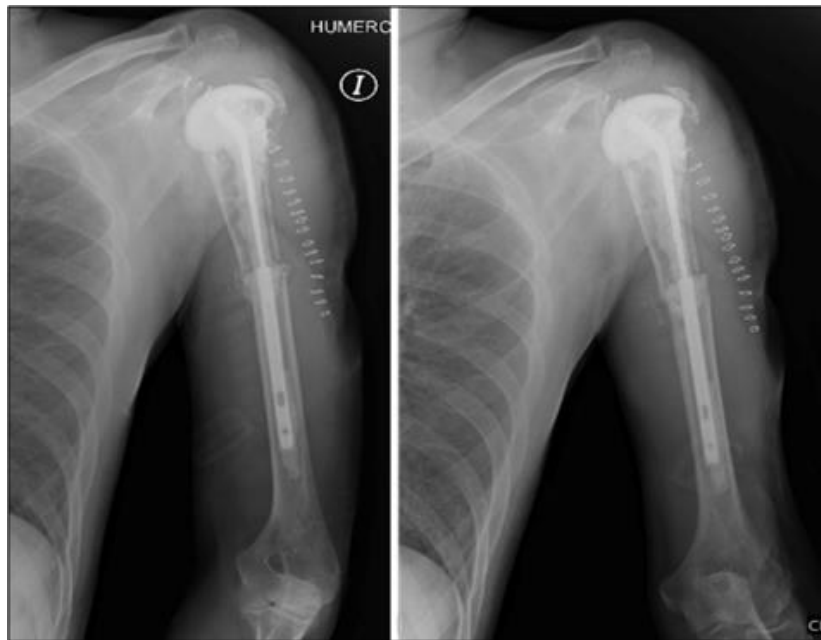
Immediate postoperative left humerus X-ray
